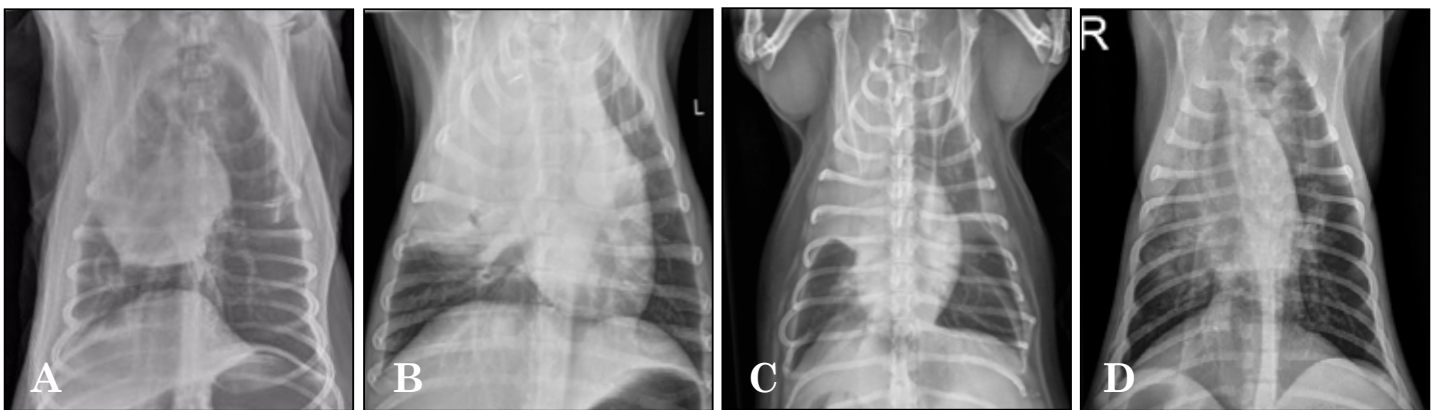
Ventrodorsal radiographs. Note the similarity in diffuse soft tissue opacity throughout the right cranial lung lobe. A) Atelectasis B) Primary pulmonary neoplasia C) Lung lobe torsion D) Lobar pneumonia
